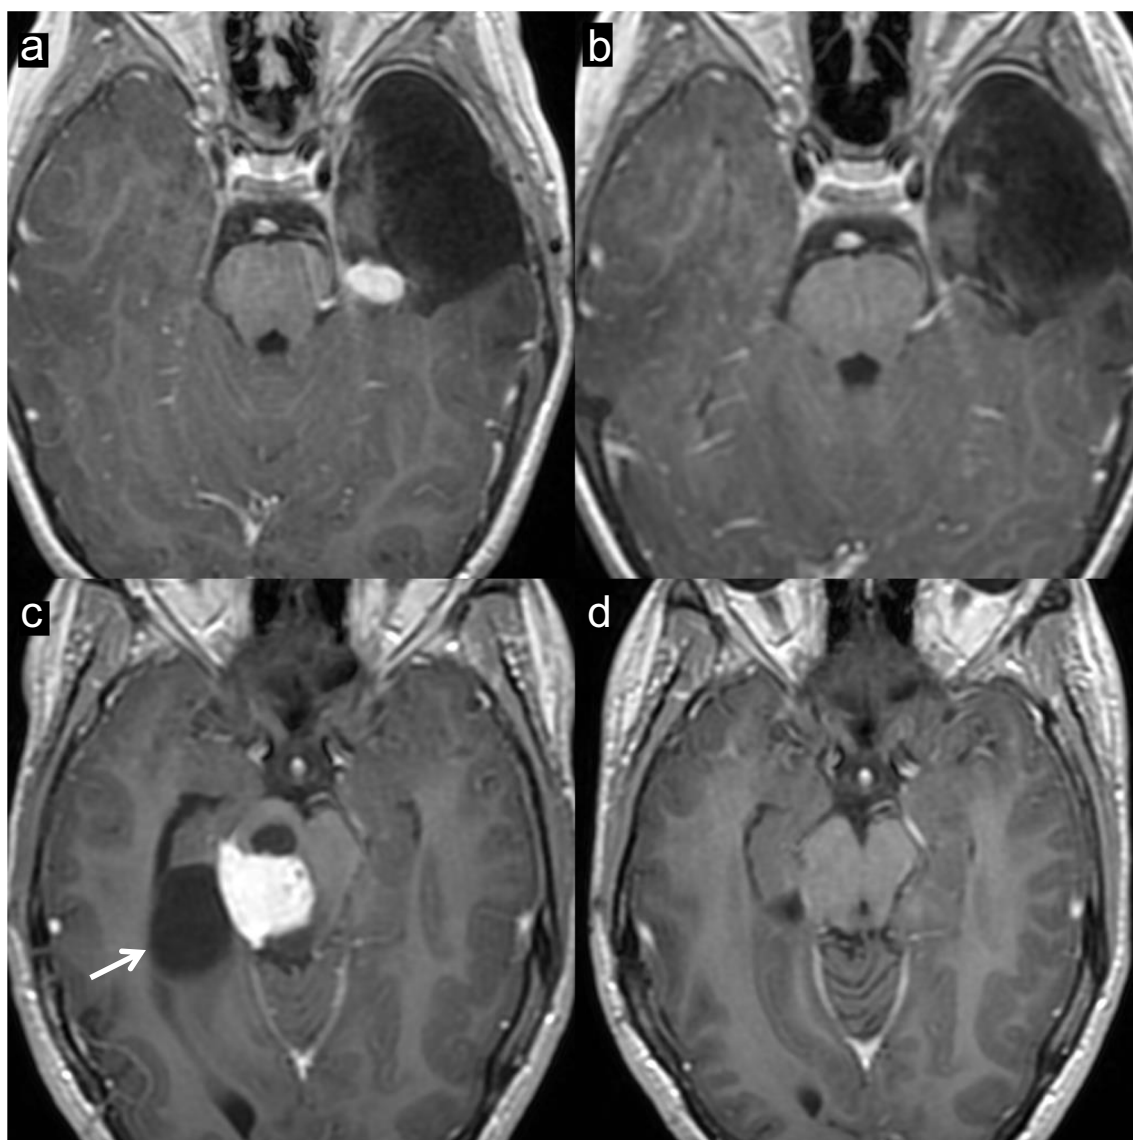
MRI axial T1 + gadolinium in patient 1 pretreatment (a) and posttreatment (b) and in patient 2 (c pretreatment and d posttreatment). There is a complete response in both patients. In patient 2 the lateral cystic component (c, white arrow) was surgically treated
